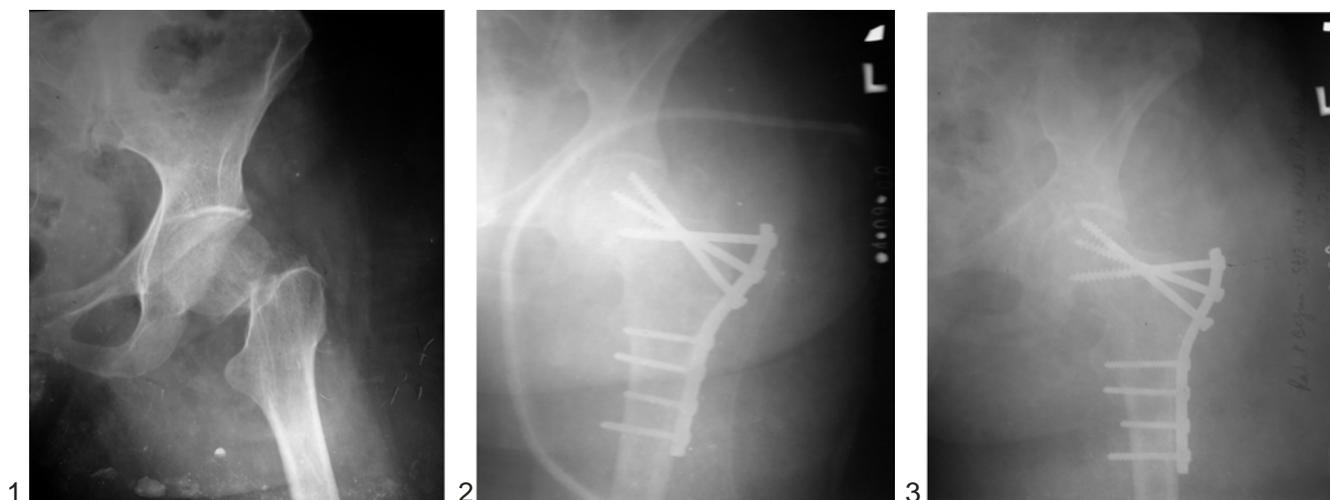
Preoperative and post operative x-rays of one of the patients
